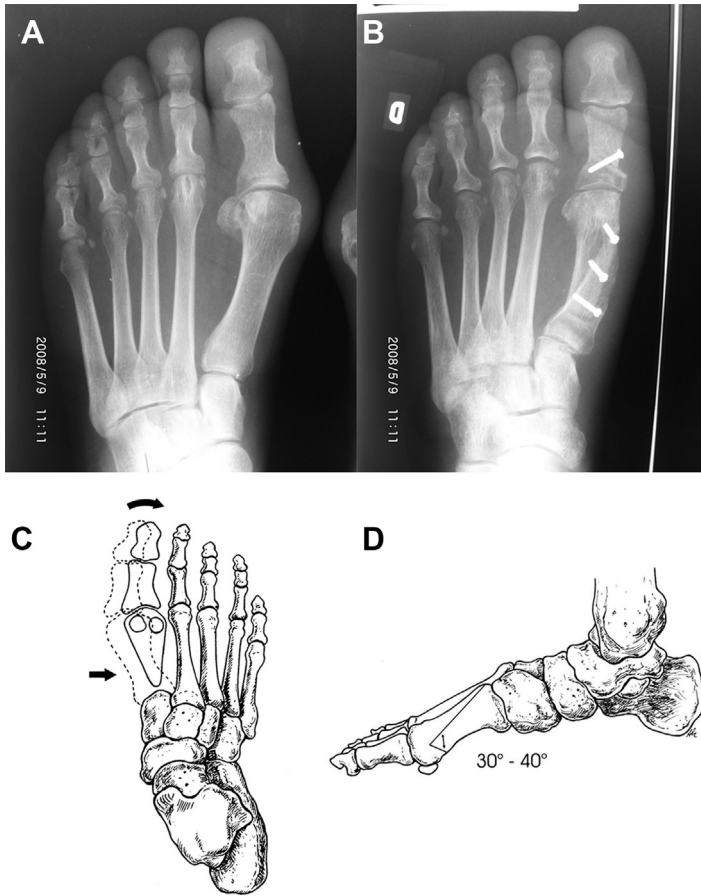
(A, B) Radiographic examinations of severe hallux valgus deformity corrected with the modified chevron technique. The apex is distal, but the upper arm of the osteotomy reaches the proximal metaphysis, traversing the entire diaphysis. (C, D) The technique. ([C,D] From Sanhudo JA. Correction of moderate to severe hallux valgus deformity by a modified chevron shaft osteotomy. *Foot Ankle Int.* 2006; 27(8):581-5; with permission.)
